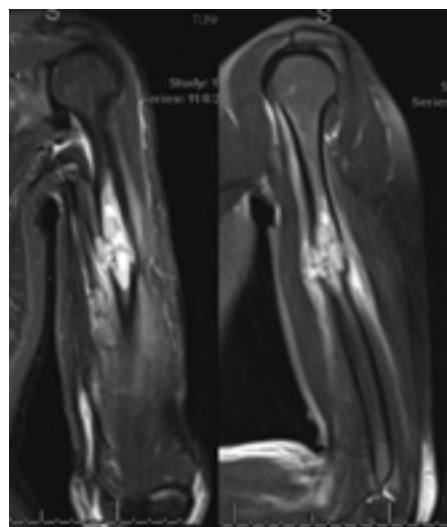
Coronal and sagittal T2 MRI sequences with expansile intramedullary lesion and small soft tissue component.
